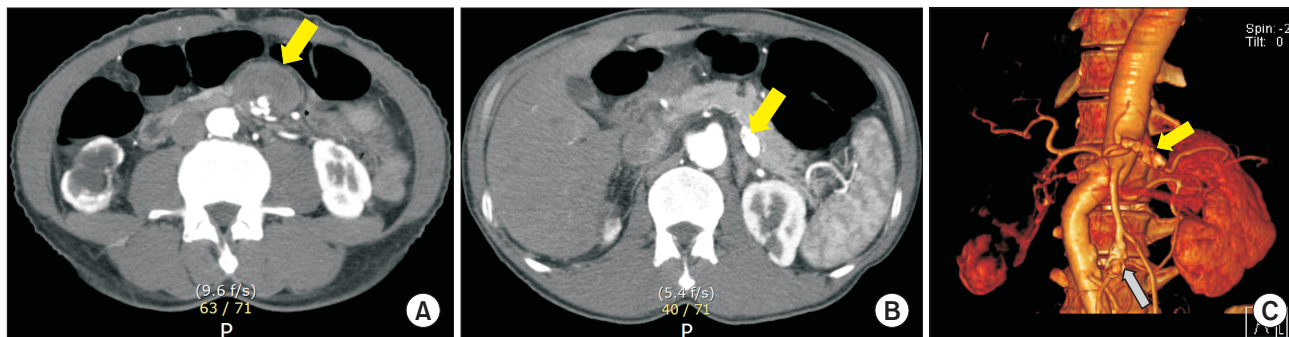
Computed tomography angiography: the arrow indicates the superior mesenteric artery aneurysm (A), the arrow indicates the splenic artery aneurysm in the axial view (B) and 3-dimensional volume rendering reconstruction (C).
